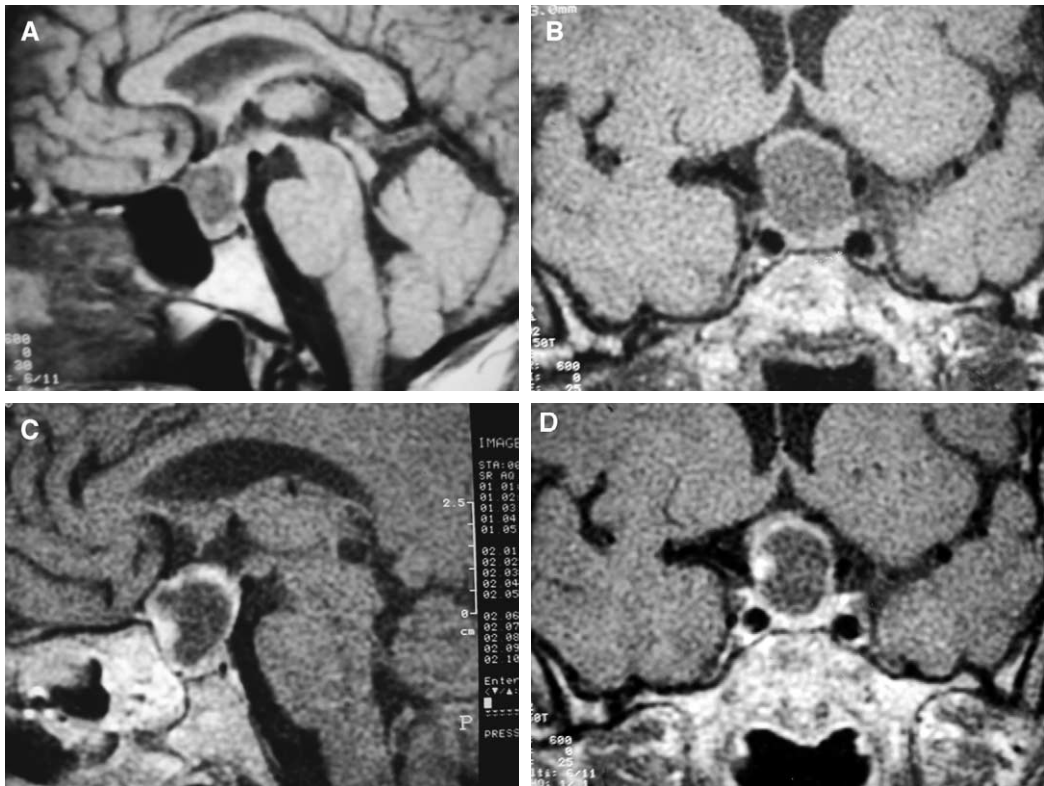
Craniopharyngioma. (A) Sagittal T1-weighted image shows a cystic mass in the suprasellar region. (B) Coronal T1-weighted image shows a large cystic mass in the suprasellar region with compression of the optic chiasm. (C) Coronal postcontrast T1-weighted image shows enhancement of the irregular cyst wall. (D) Sagittal postcontrast T1-weighted image demonstrates enhancement of the cyst wall with a nodular area on the right side.
